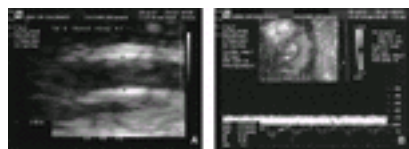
The formula for measurement of umbilical venous flow is shown. A: On ultrasound, how to obtain umbilical vein diameter (note that the calipers are placed just inside the specular reflections). B: On ultrasound, how color is used to ensure an angle of insonation at nearly 0 degrees and how Doppler velocimetry is used to obtain a steady umbilical vein waveform velocity. See color figure 12.9.
